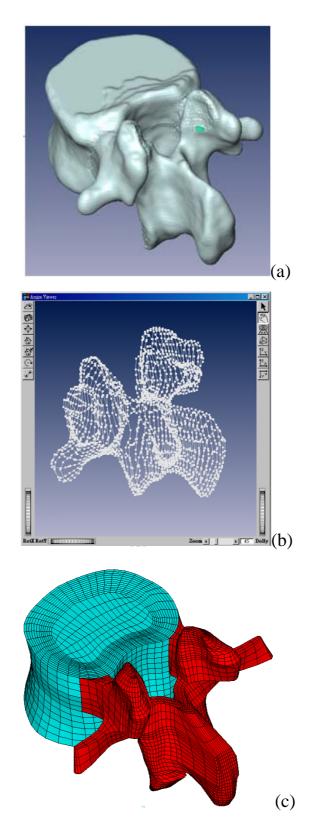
Modeling process of the L3 vertebra: (a) surface geometries of the L3 vertebra were reconstructed through sequential processed computed tomography scan DICOM files; (b) surface geometry was exported to the DXF file; (c) FE model of the L3 vertebra.
